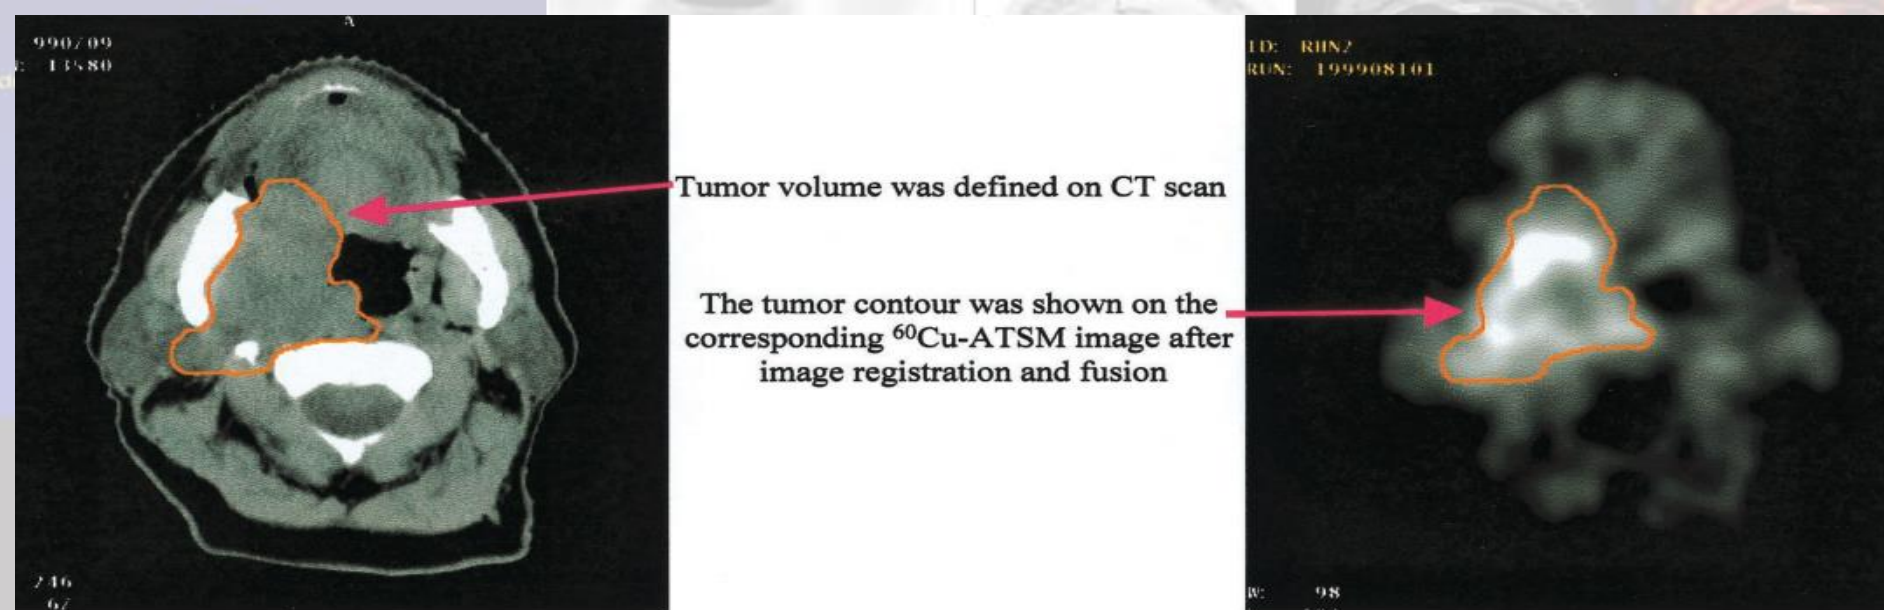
Delineation of the gross tumor volume and its ATSM-avid fraction by CT-PET imaging fusion.
